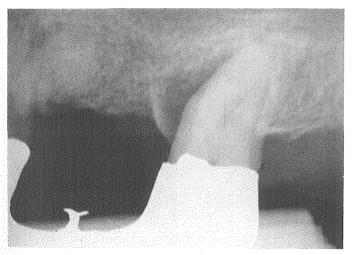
A recent roentgenogram of the infrabony pocket.
